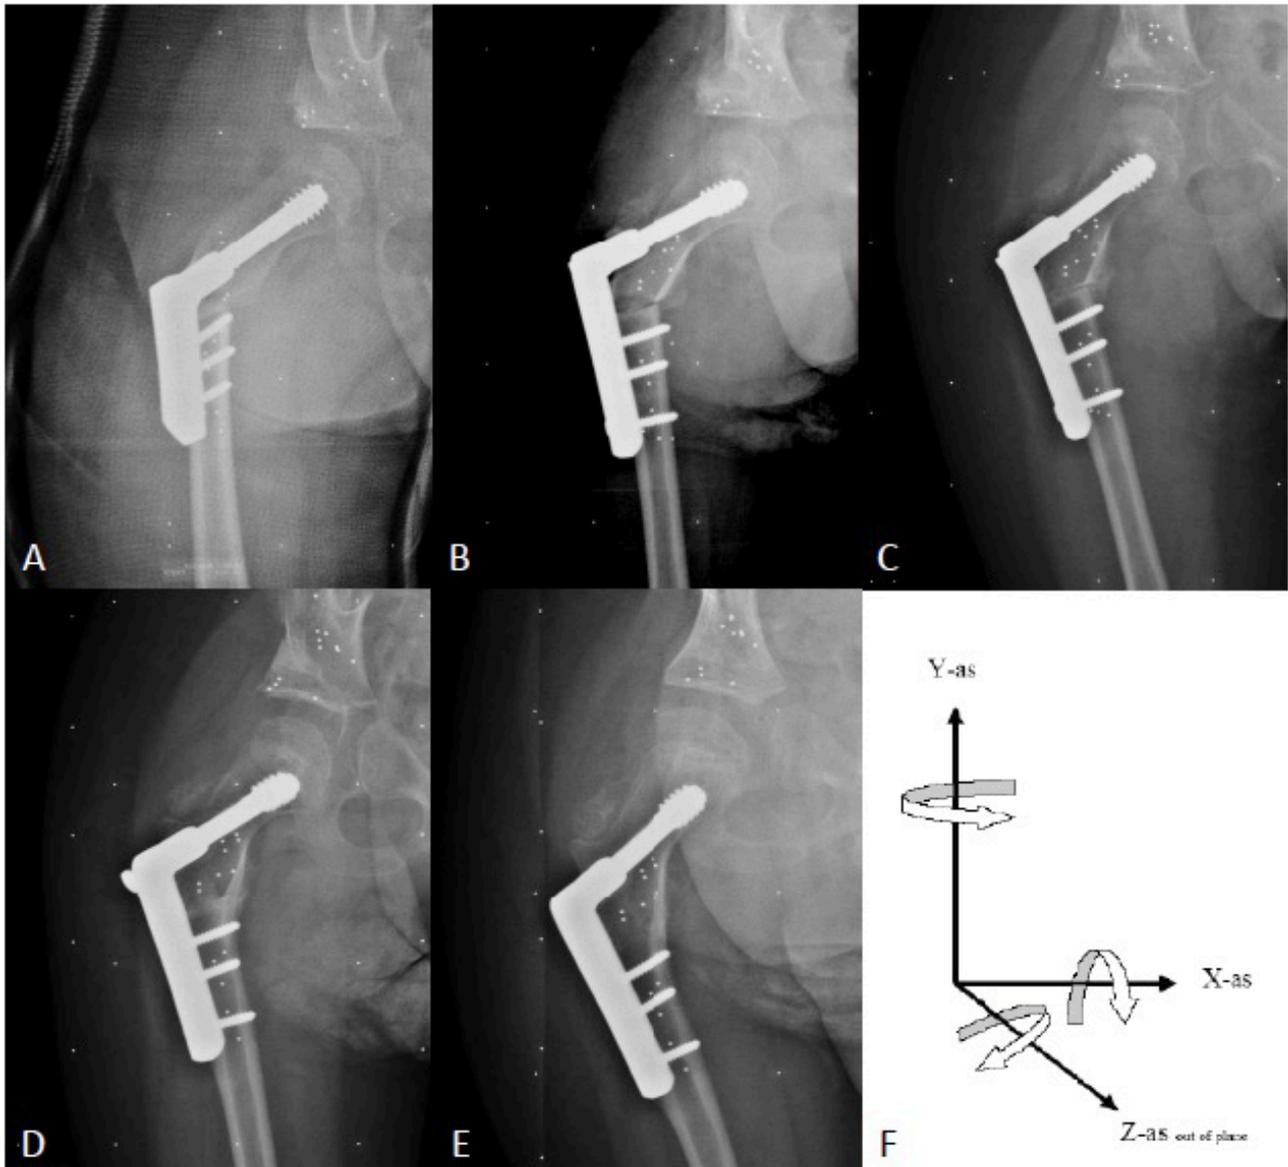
A-E: RSA radiographs at postoperative time 0 weeks, 5 weeks, 3 months, 6 months and 12 months, respectively. In figure D and E the VDRO is considered radiographic stable. F: Shows the orientation of the 6 degrees of freedom with positive values of a right distal femur distal. Hence, translations x_+ = medial, y_+ = superior and z_+ = anterior and rotations Rx_+ = anterior tilt, Ry_+ = internal rotation and Rz_+ = varisation.
